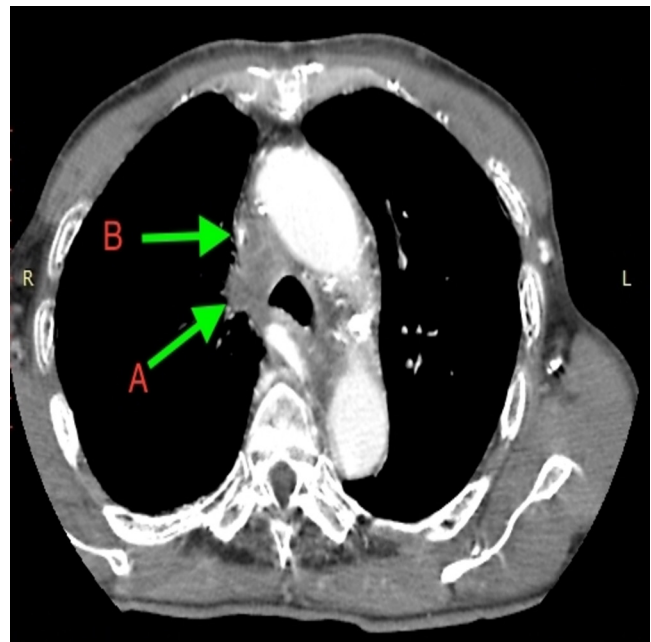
Non-contrast CT axial image of patient demonstrates mediastinal mass (A) and compressed superior vena cava (B)
